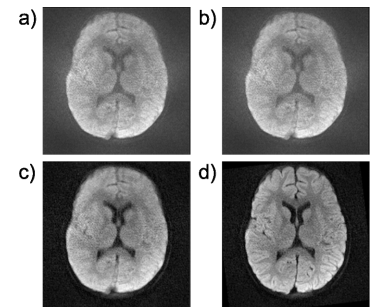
Isotropic DWI of Patient B. Same panel setup as in Fig. 3. Unlike Pat. A, this patient did not move right at the start of the scan, why the image quality in a) and b) are similar. The motion corrected and complex averaged data is given in d)
